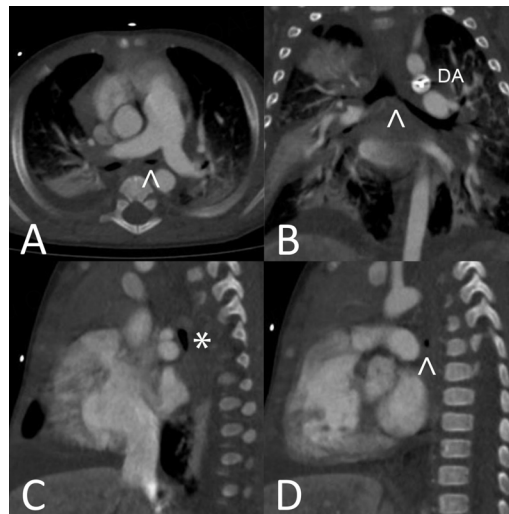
Images from a CT angiogram of the chest of the incident patient at 7 months of age (3 months after device closure of the ductus arteriosus). (A) An axial image showing a large MPA, mild to moderate flattening of the right bronchus, and severe flattening of the left bronchus (arrow) between the right pulmonary artery, descending aorta, and mildly curved spine; (B) A coronal image showing a device in the DA and a very small proximal left bronchus (arrow); (C)* A sagittal image showing mild to moderate flattening of the right bronchus; (D) A sagittal image showing severe narrowing of the left bronchus (arrow). DA: ductus arteriosus.
